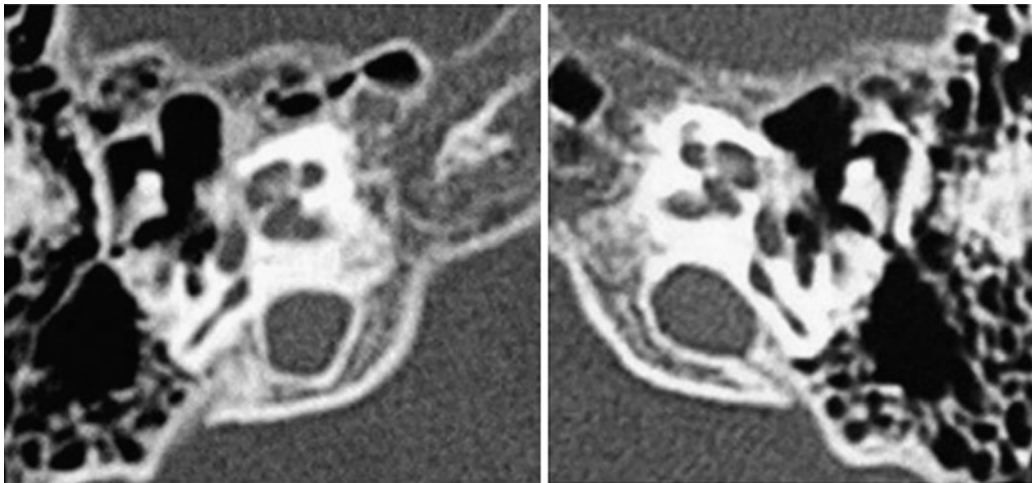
Pre-operative CT findings (both side ears) of case 1.
